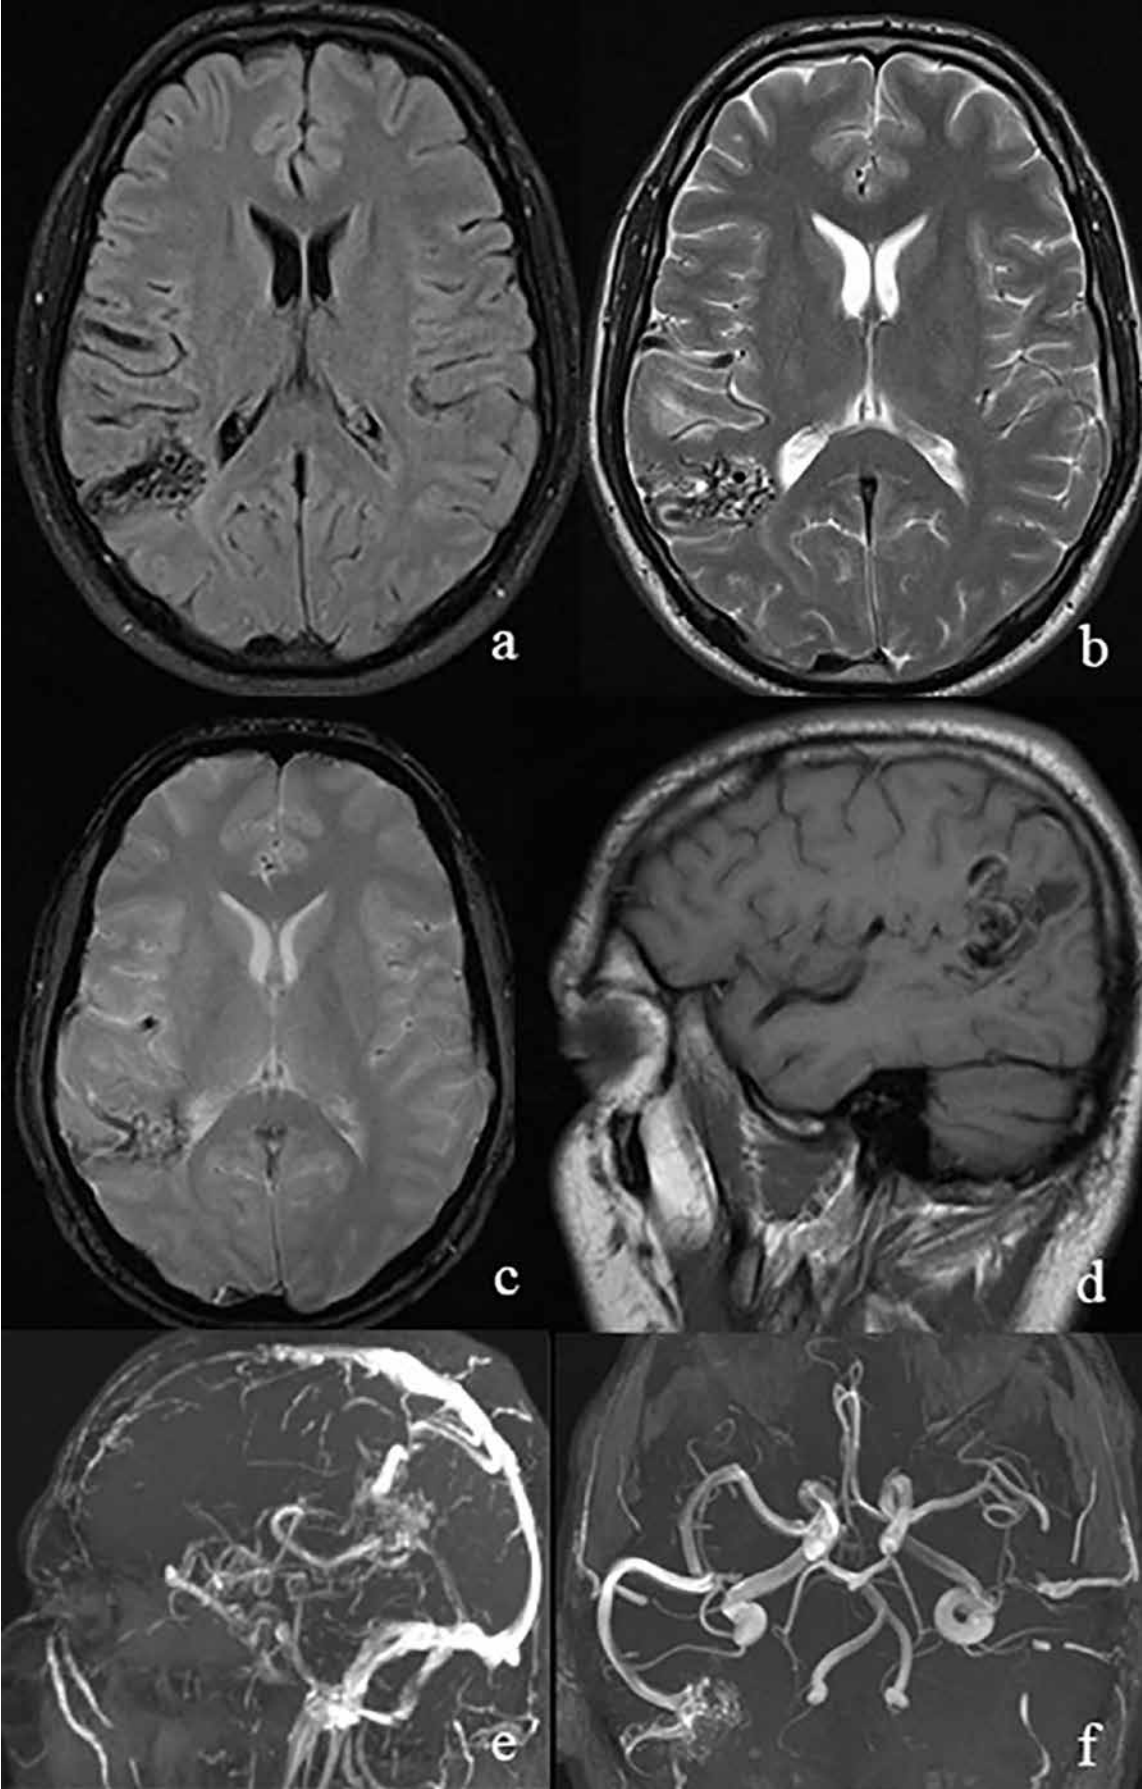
Arteriovenous malformation, MRI (a - T2W FLAIR axial; b - T2W axial; c - T2W f12d hemo axial; d - T1W sagittal; e - TOF vein; f - TOF arterial).
